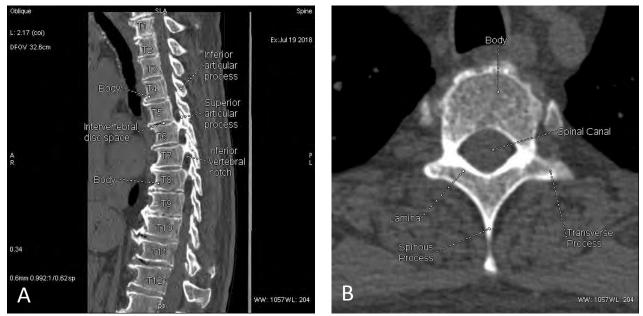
Thoracic spine. (A) Sagittal MPR (B) Axial CT.
